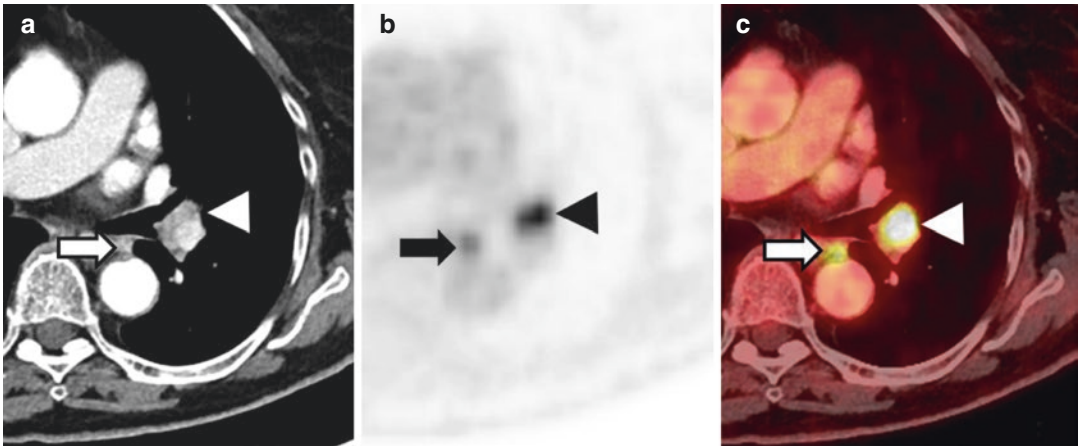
High sensitivity of FDG-PET demonstrated in a case of adenocarcinoma originating from the left lower lobe with N2 disease involving lymph nodes at the left hilum (visibly enlarged at CT, *arrowhead*) and a normal
